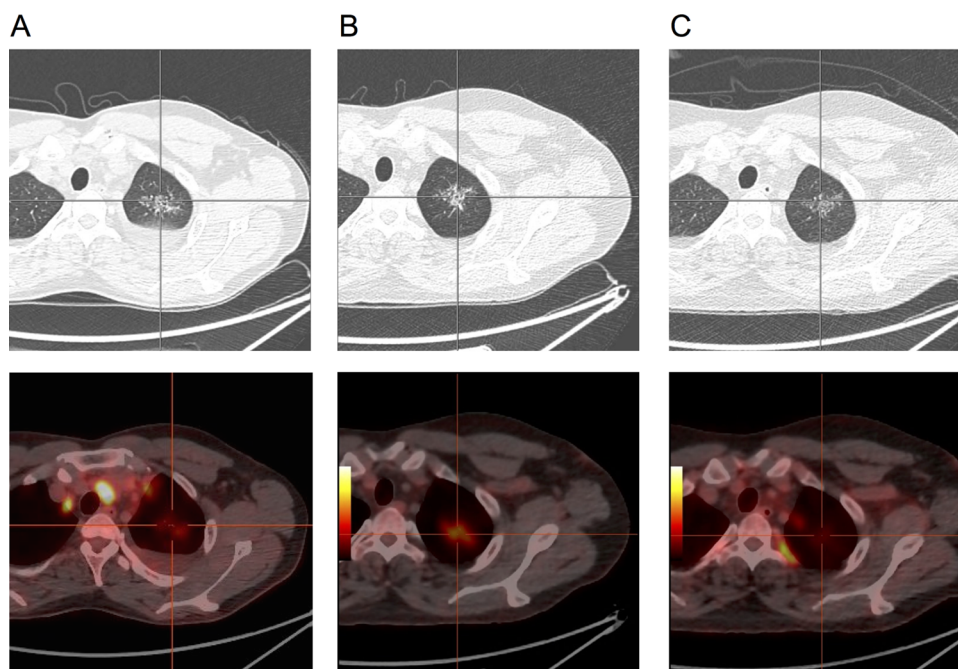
(A) CT and positron emission tomography (PET) before treatment including pathological mediastinal lymph nodes; (B) CT and PET after 2 months of treatment; (C) CT and PET 4 weeks after treatment of the lymphoma and after 3 months of antibiotic treatment of the pulmonary actinomycosis.
